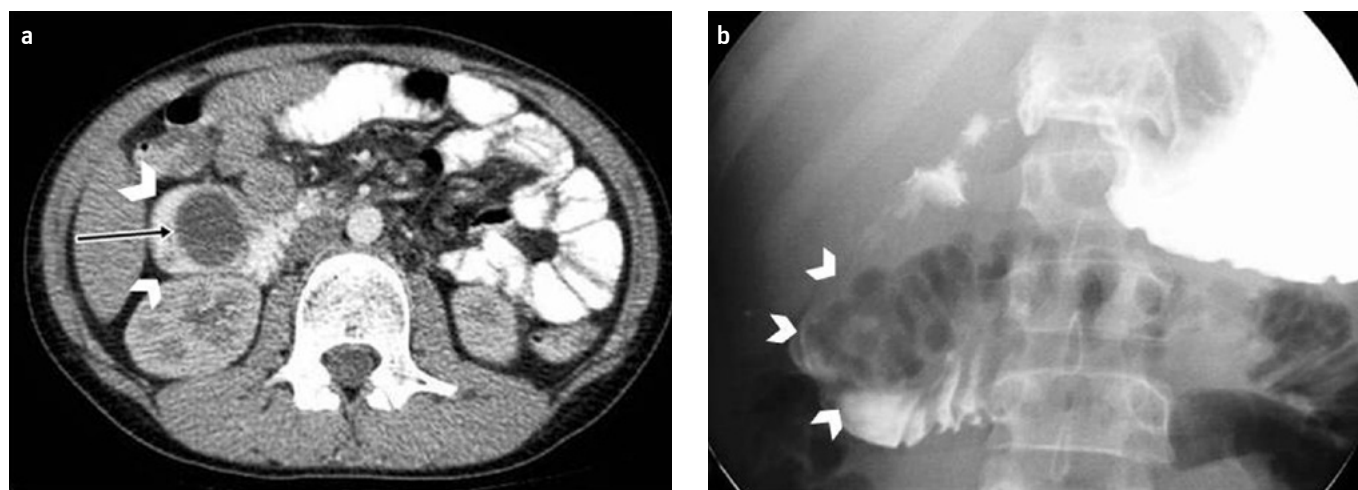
a, b. Abdominal computed tomography revealed a slightly thick-walled, well-defined, 52x38x27-mm cystic mass (long arrow) protruding into the second portion of the duodenum (arrow heads) (a), a gastrointestinal contrast study revealed an obscure limited filling defect that was considered to represent external compression at the medial and second portions of the duodenum (arrowheads) (b), the compression did not result in a significant obstruction.
